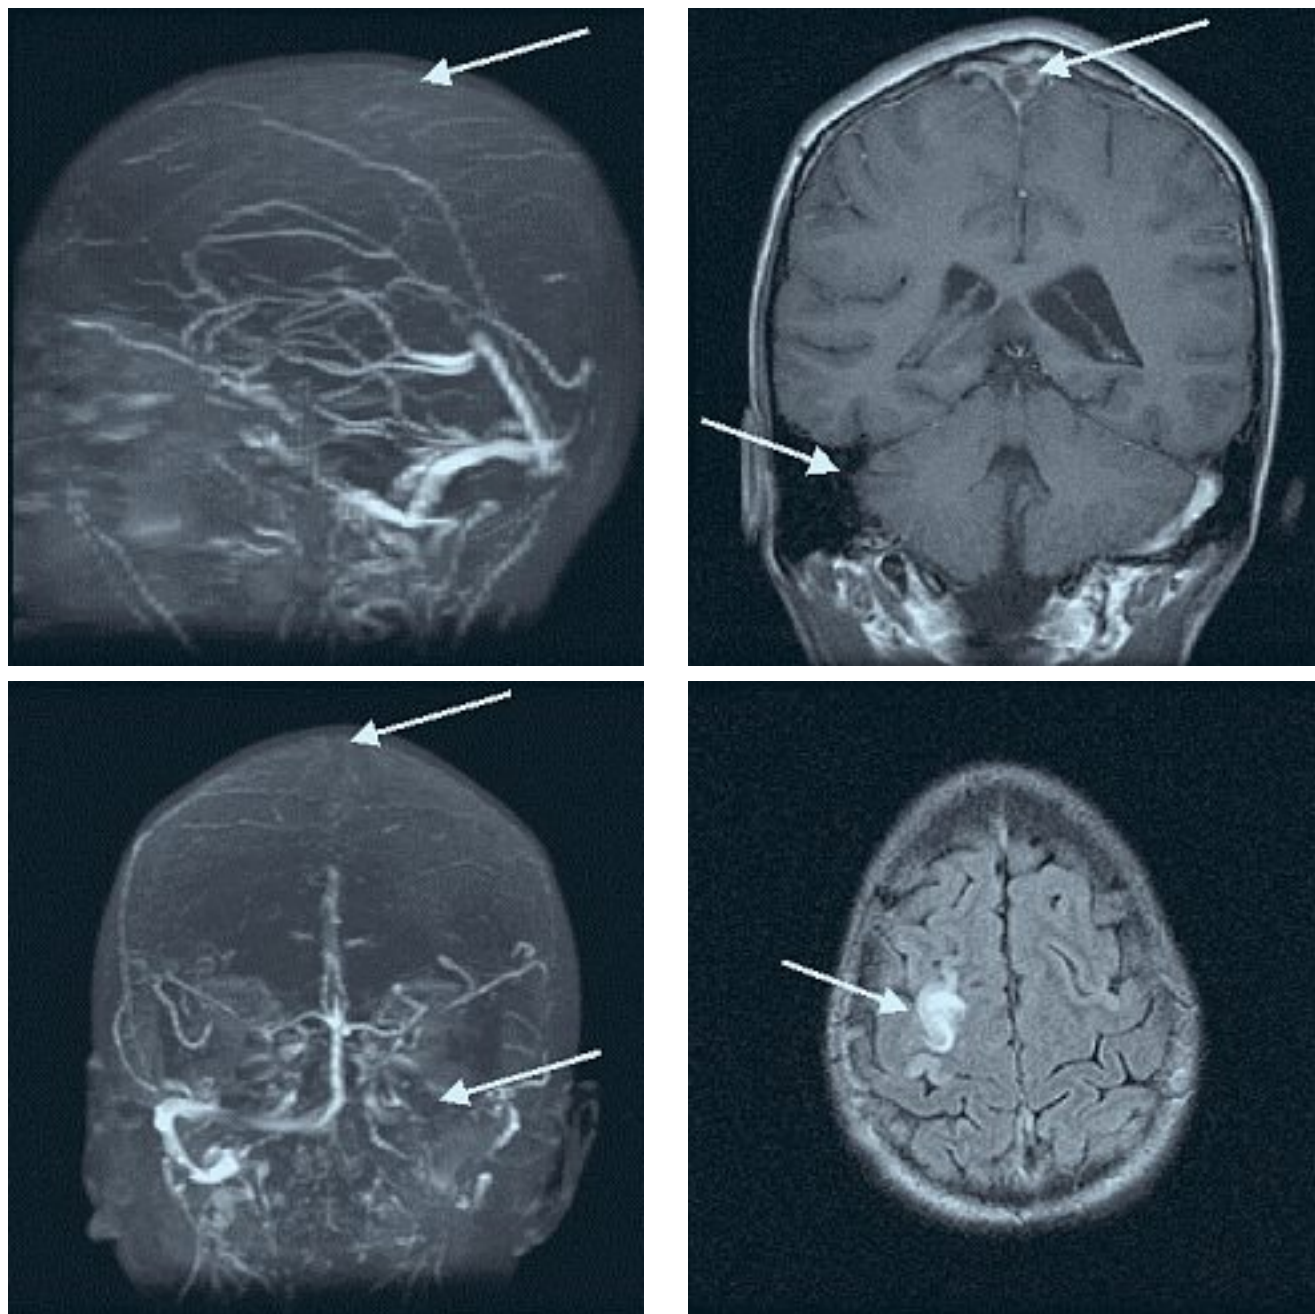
Cerebral Venous Sinus Thrombosis. MR images of head without/with gadolinium including axial FLARE images, axial diffusion-weighted images, and MR venography of the major dural venous sinuses. Acute thrombosis (arrows) can be seen throughout the superior sagittal sinus extending into the left transverse sinus and portions of the left sigmoid sinus (Figure 1A-C). An acute venous infarct is evident involving the posterior frontal lobe near the vertex (Fig. 1D)
